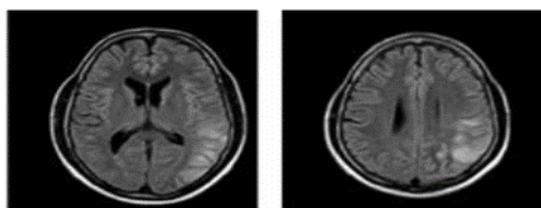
Brain MR image (samples)
